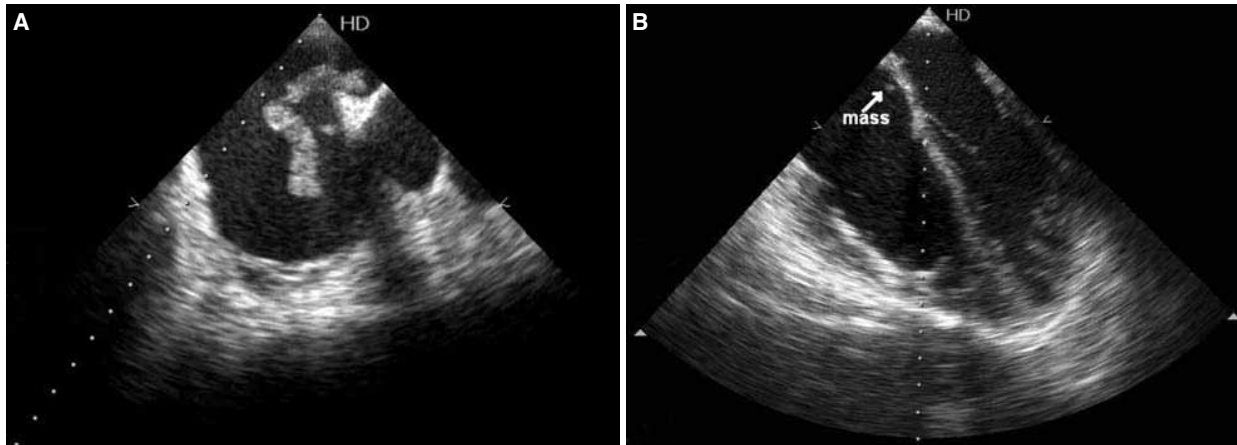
(A) Transesophageal echocardiography (TEE) showing a right atrial mass in the patent foramen ovale. (B) Intraoperative TEE showing the decreased size of the mass due to anticoagulation.
